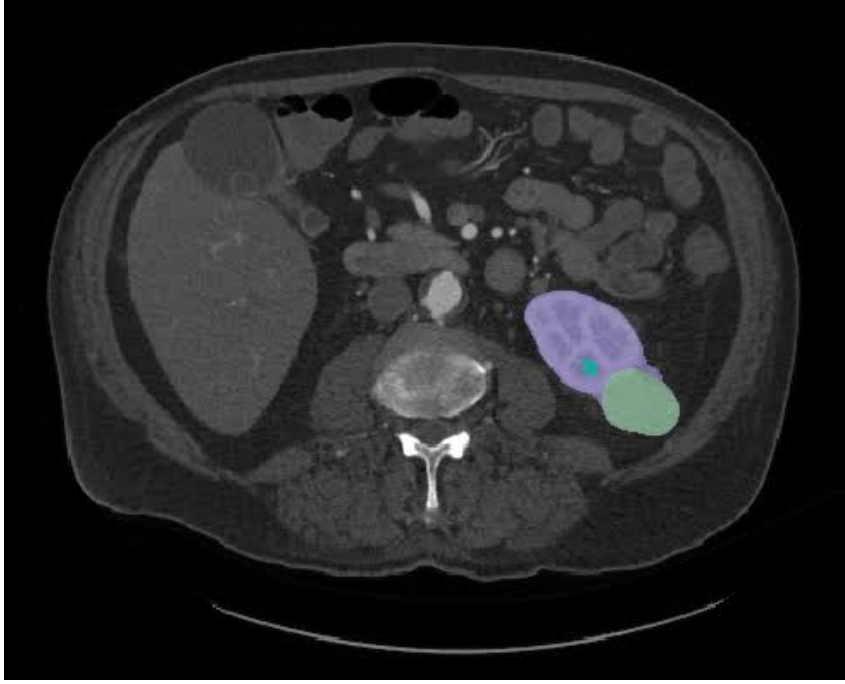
Example annotated axial CT slice from the KiTS23 dataset showing kidney (purple), tumor (green), and cyst (blue) labels [1].
